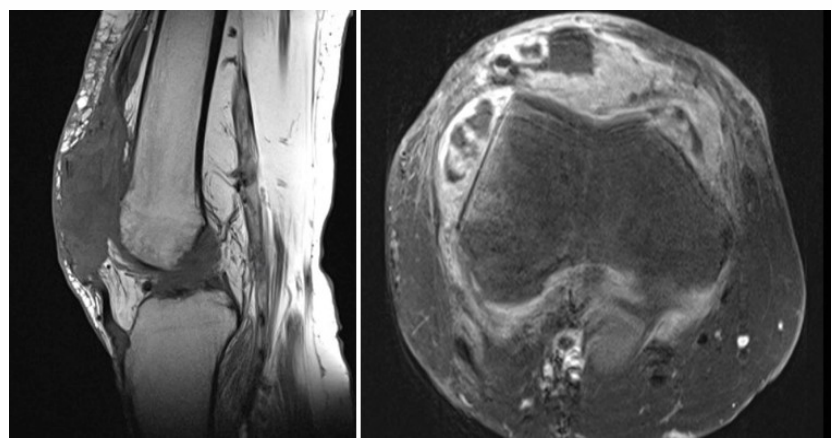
Repeat Magnetic resonance imaging Sag T1 (a), and contrast-enhanced Fat suppressed Ax T1 (b) demonstrated a homogenous enhancement of the distal pole of the patella and complex effusion with thickened, enhancing synovium through the joint space. Differential diagnosis included continued metastatic disease, osteonecrosis, or osteomyelitis in the patella with joint inflammation or infection.
